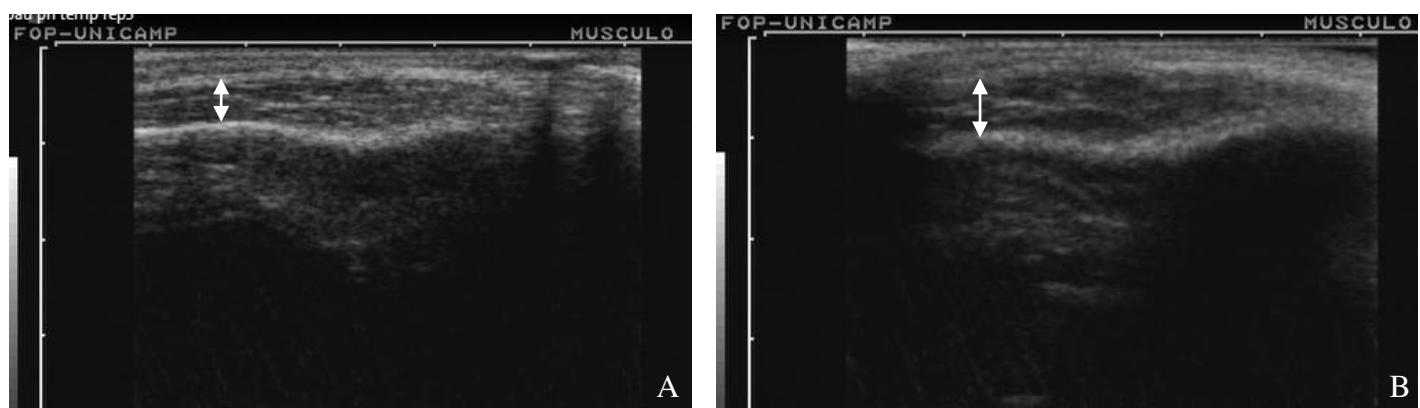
Ultrassonografia do músculo temporal (parte anterior) em repouso (A) e durante apertamento dentário (B). As flechas indicam a espessura muscular mensurada.
